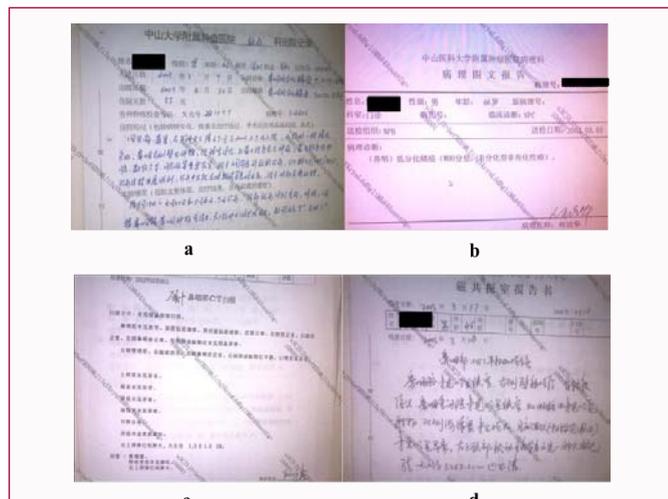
Case data of the patients treated NPC in Sun Yat-sen University Cancer Center in 2003. a) The discharge summary of the patients, including patient diagnosis and radiotherapy program. b) Pathological diagnosis of the patients. c) The diagnosis report of the enhanced CT scan of neck and nasopharynx. d) The diagnosis report of the enhanced MRI of nasopharynx.
